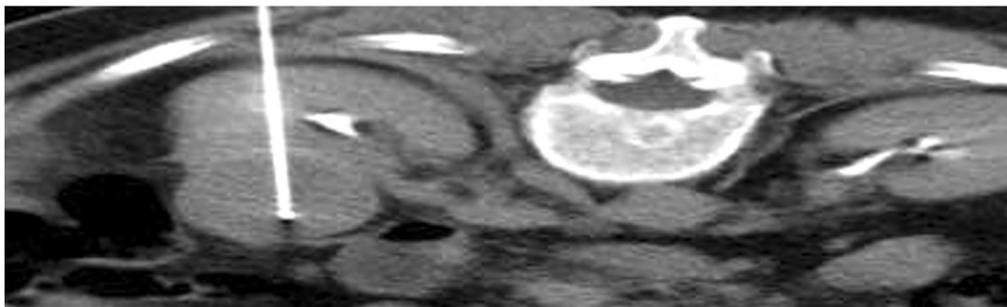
Patient in a prone position and axial CT scan at delayed phase obtained shows RF needle electrode within the tumor.
